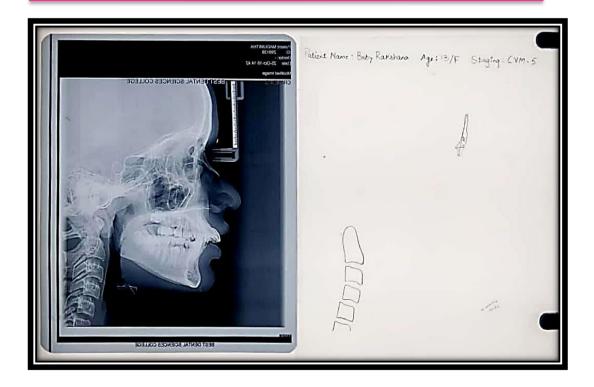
Traced sheet of the radiograph
